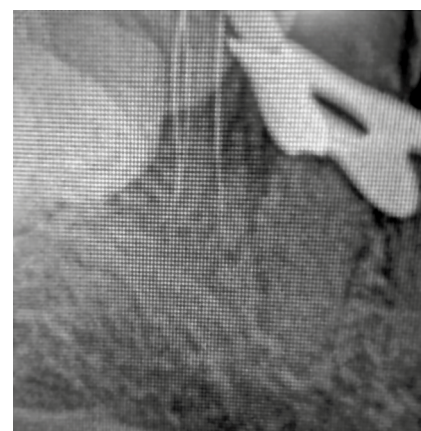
Second working length radiograph
